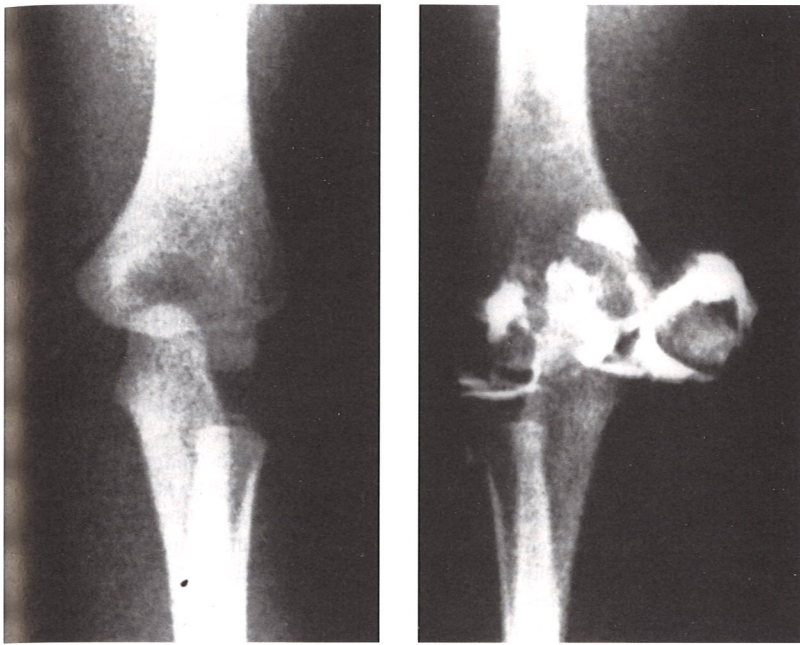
Left, On radiograph this fracture appears to be a small displaced fracture of the medial epicondyle. Right, Arthrogram shows fracture of the medial condyle.
